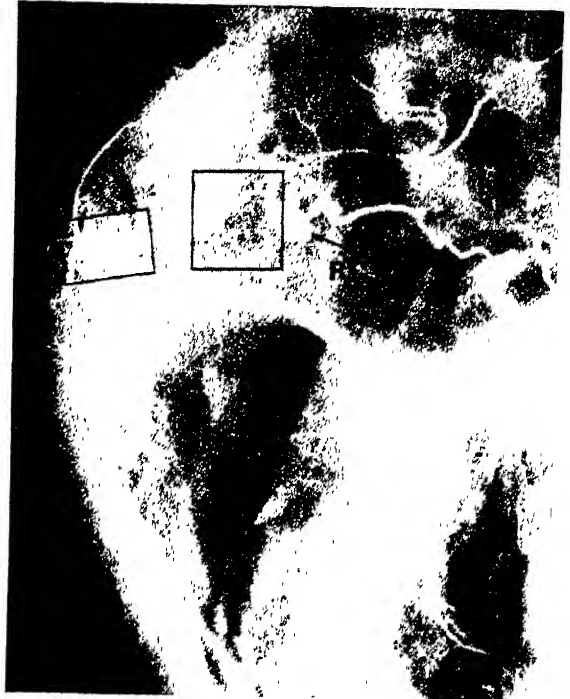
Post-mortem radiograph of part of the right coronary artery in a case of angina. Shortly after its origin (*arrow*), a length of the artery is occluded (*square*) and adjacent vessels have enlarged to provide a collateral route, so that the artery is filled beyond the occlusion. A second occlusion (*oblong*) is present, but is partly obscured by the curving course of the artery. (Professor M. J. Davies.)
